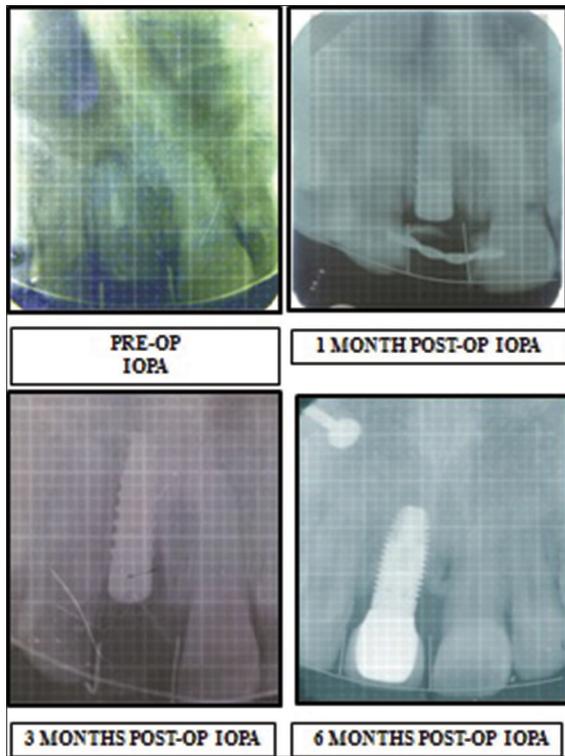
Radiographic assessment
